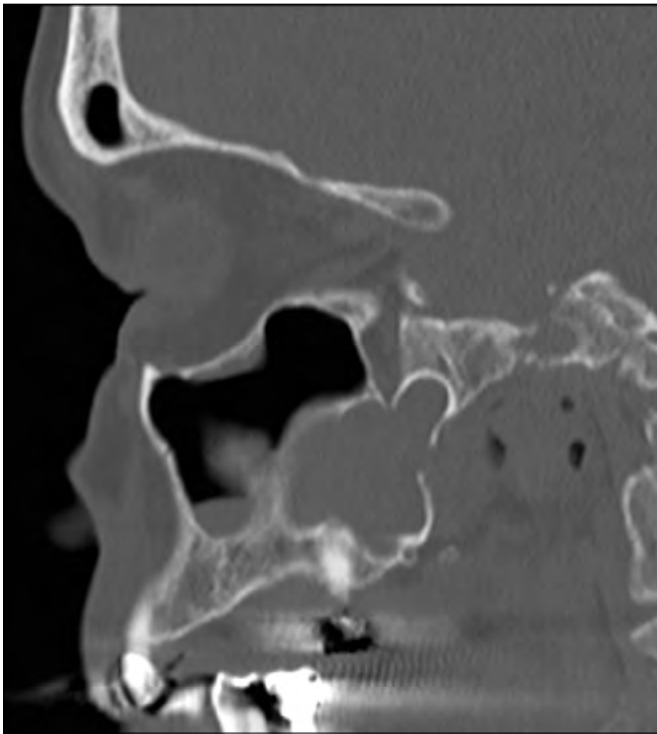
Sagittal CT image showing an odontogenic cyst extending into the body of the sphenoid sinus. Odontogenic sinonasal pathology could represent a matter of difficult differential diagnosis in some patients. A strict collaboration between otolaryngologist and dental specialist is often therefore required also in diagnostic terms.
